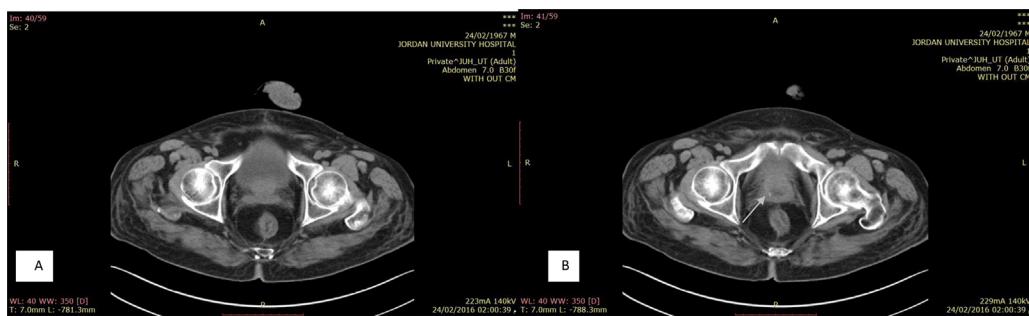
Axial non-contrast urinary tract CT (A+B) show near completely removal of all stones (residual tiny stone in the prostate, arrow).
